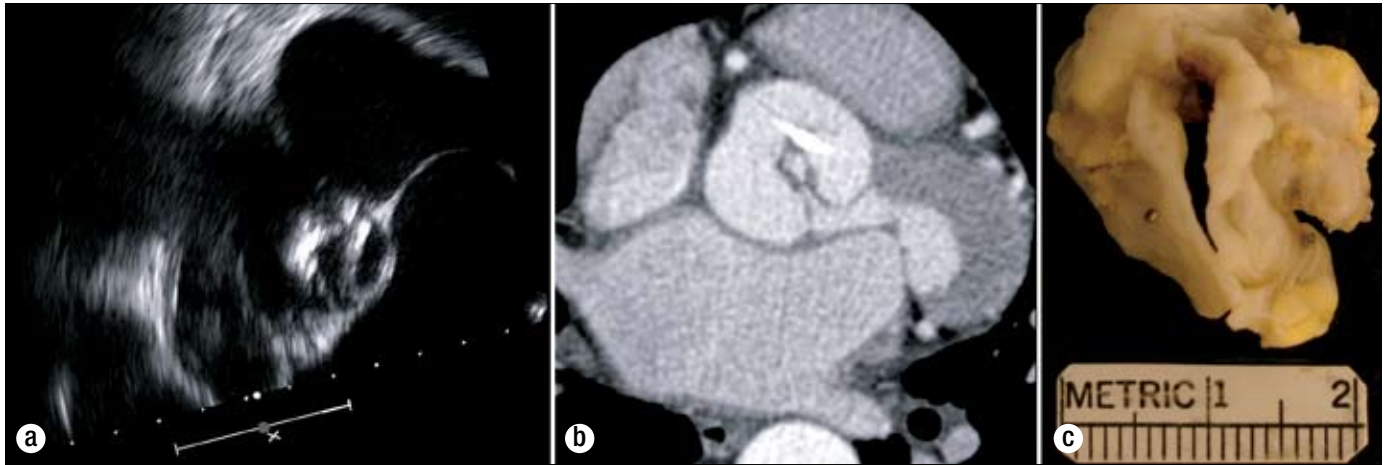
Unicuspid aortic valve evaluated with (a) transesophageal echocardiography, (b) computed tomography, and (c) gross pathology.
